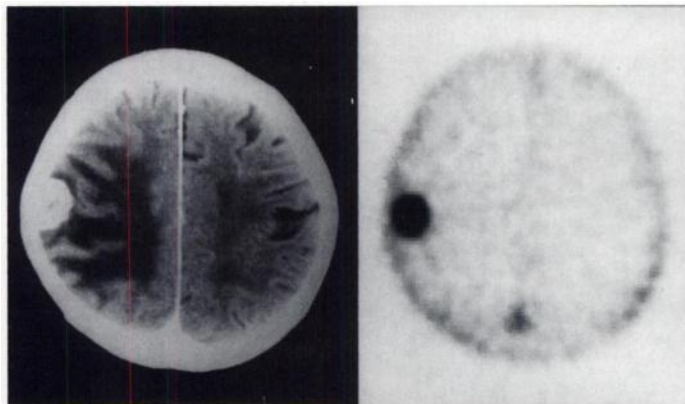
Patient 3 with a brain tumor caused by metastasis of lung cancer (adenocarcinoma) CT with enhancement (left) and PET with $[^{11}\text{C}]$ choline (right). Tumor-to-normal brain $[^{11}\text{C}]$ choline uptake ratio, 10.7; tumor-to-normal brain CBF ratio, 0.9.
